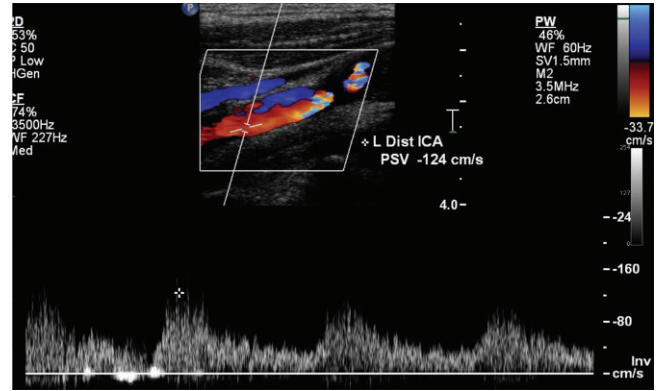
Spectral duplex Doppler beyond the site of narrowing shows a red color indicating a lower velocity. This is confirmed by the spectral Doppler that shows a PSV of 124 cm/s. The edge of the waveform has numerous spikes. This is termed a picket fence appearance and it is produced by turbulent poststenotic flow.
